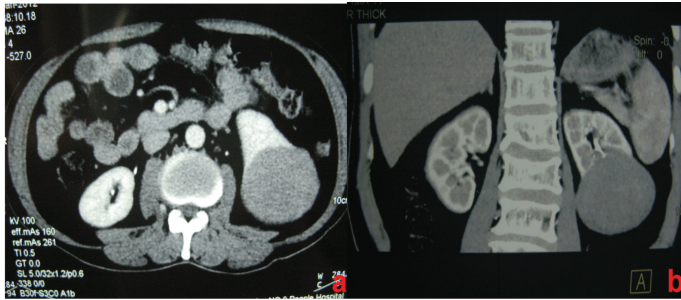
Contrasted computed tomography (CT) reveals solid left renal mass with mild contrast enhancement. There is an absence of enlarged retroperitoneal or mesenteric lymph nodes.
